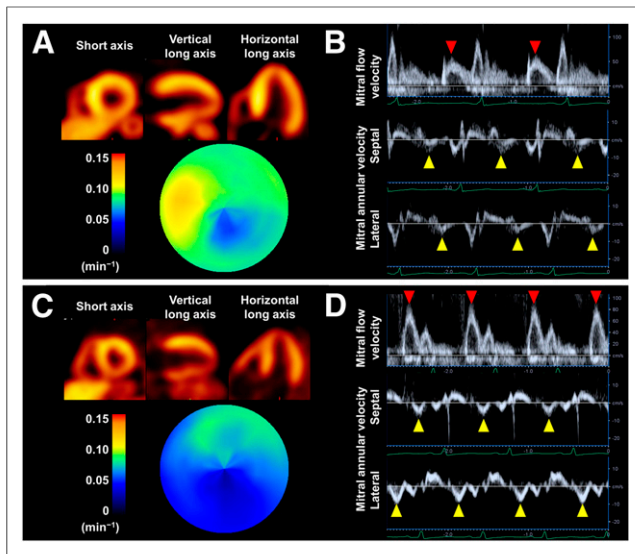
Representative images of ^{11}C -HED PET (A and C) and Doppler echocardiography (B and D) in 2 HFpEF patients (patient 1 with hypertensive heart disease and grade 1 diastolic dysfunction [A and B]). In patient 2 with cardiac amyloidosis and grade 2 diastolic dysfunction (C and D), the polar map of ^{11}C -HED RI (C) shows more extensive impairment of myocardial sympathetic innervation than that of patient 1 (A). Red arrowheads indicate E wave, and yellow arrowheads indicate e' .
